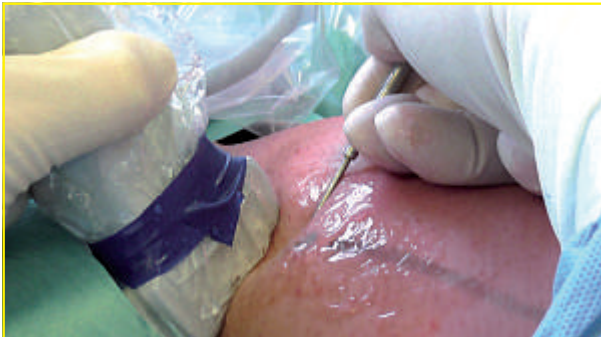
Inguinal exteriorization of the saphenous trunk with ultrasound monitoring.
